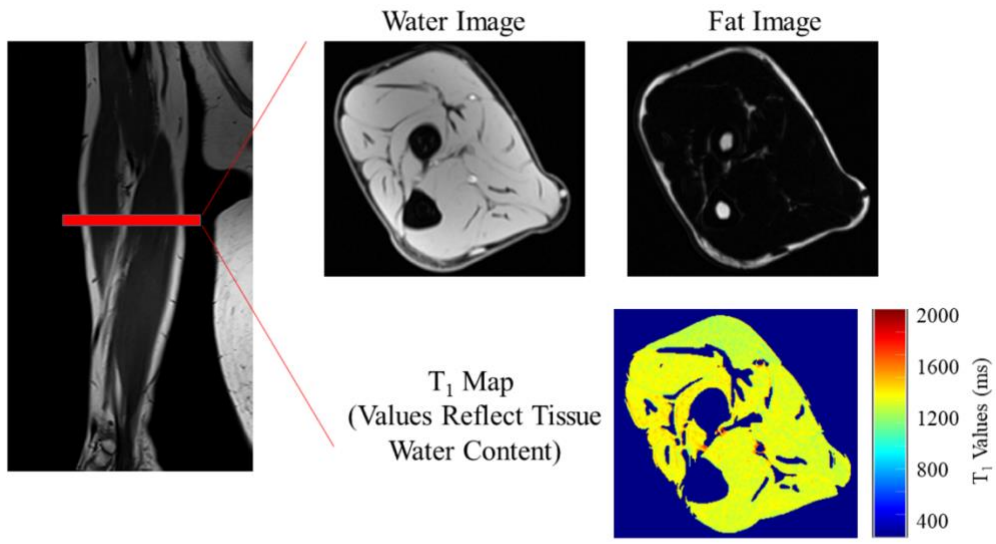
Magnetic Resonance Imaging - one sample slice
